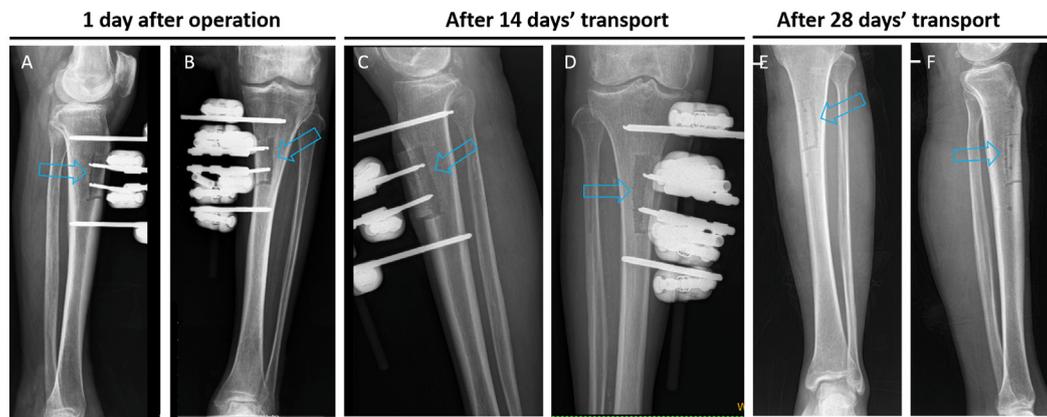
These postoperative radiographs show the procedure of TTT (A–B) The positions of corticotomy and external fixator were confirmed on AP and lateral radiographs 1 day postoperatively (C–D) After 2 weeks of medial distraction, the osteotomies cortex reached the maximum transport, splitting at the tibia (E–F) This was followed by 2 weeks of lateral transport returning the cortex to its original position, after which the external fixator was removed.
